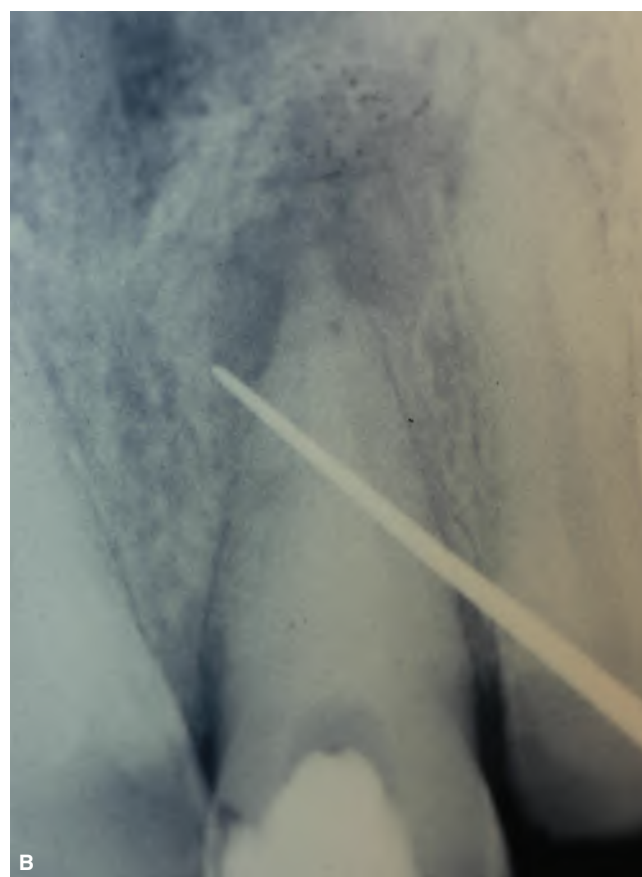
Trephination procedure. A. A #3 spreader is used to penetrate the mucosa and cortical plate. B. Radiograph showing tip of #3 spreader near root-end. (Courtesy of J. Craig Baumgartner, Kailua, HI, U.S.A.)
